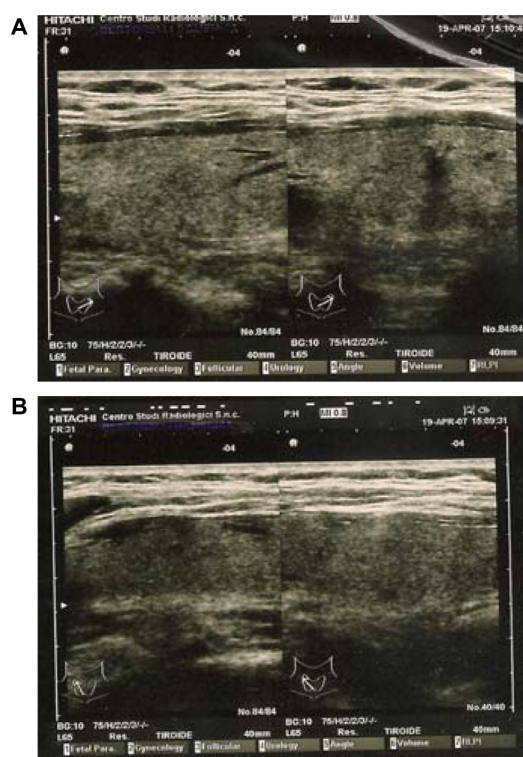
Thyroid ultrasound (during Hashimoto's thyroiditis period). (A) left lobe; (B) right lobe.
